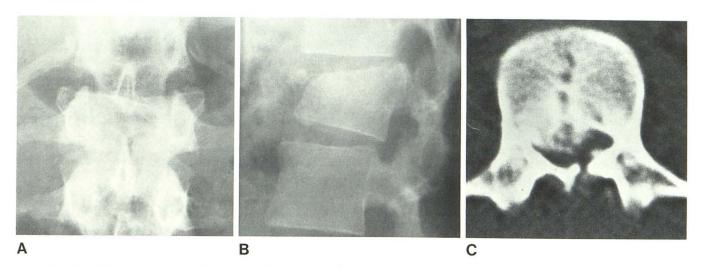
Vertebral body fracture with leg weakness due to nerve root herniation. A, and B, L1 compression with widening of pedicles and element of spinal canal compromise. C, Axial CT section. Sagittal cleavage through
